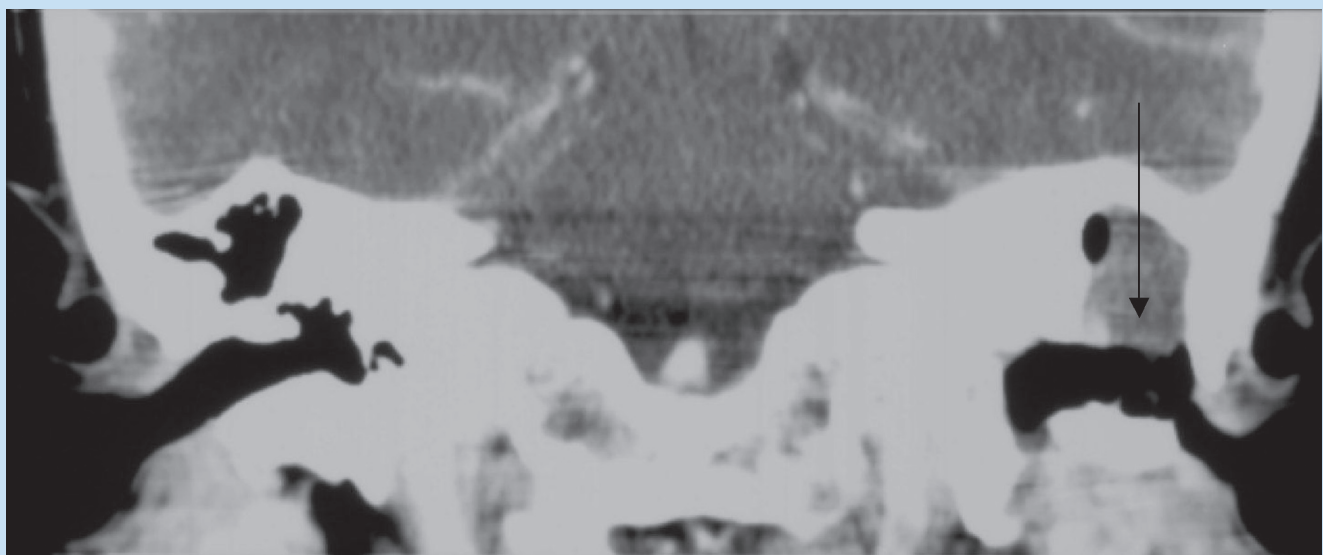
Coronal CT using soft-tissue windowing, depicting a non-enhancing soft-tissue mass (arrow).
